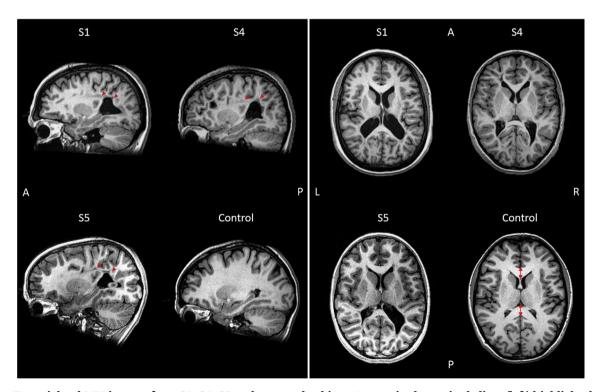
T1-weighted MRI images from S1, S4, S5 and a control subject. Arrows in the sagittal slices (left) highlight the PVL lesions and mislocalized growth of gray matter next to the parietal regions. Transversal slices (right) show the thinning of the corpus callosum with respect to the control subject, whose normal thickness is marked by the red double headed arrows. A: anterior; P: posterior; L: left; R: right.
